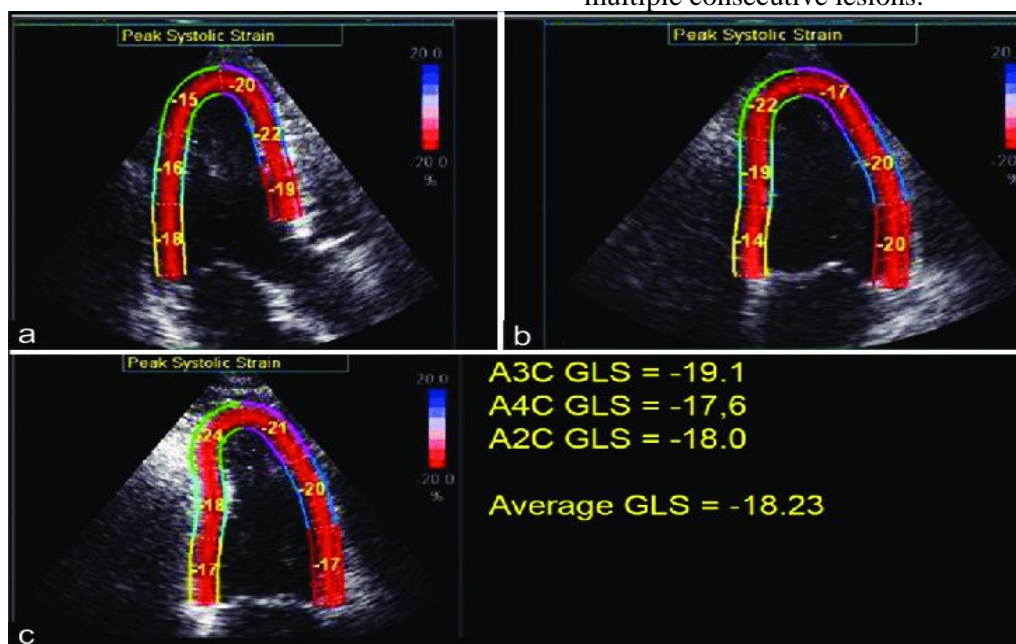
Speckle tracking echocardiography demonstrating the longitudinal strain of the basal, mid and apical segments in A3C, panel a, A4C panel b, and A2C panel c⁽¹¹⁾
